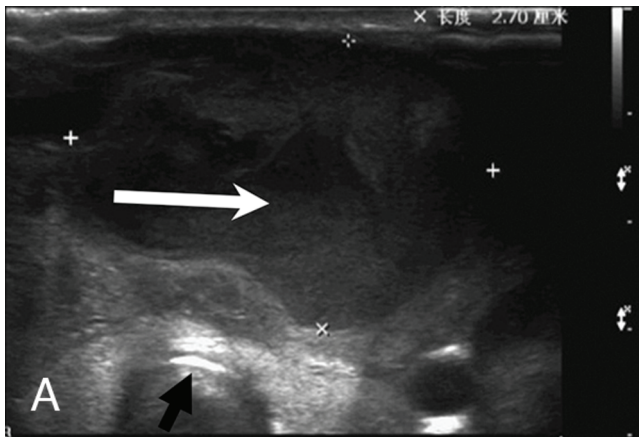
Longitudinal grayscale ultrasound image in midline of the neck demonstrates a well-defined, oval-shaped, unilocular, anechoic lesion with thick wall (white arrow) located just above the hyoid bone (black arrow). The posterior enhancement as a clue to the cystic nature of the lesion is indicated.
